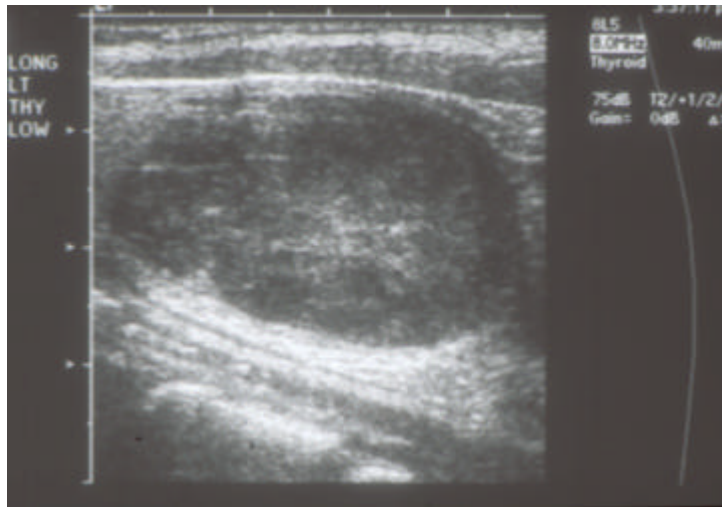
Small-part ultrasound (10 MHz) showing a 3.5 cm hypodense mass in the lower pole of the thyroid gland on longitudinal scan.
